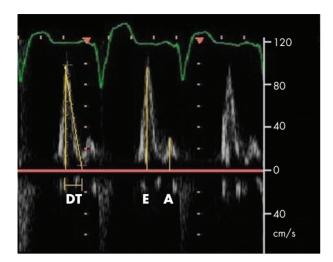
Example of restrictive mitral inflow pattern by Doppler echocardiography in a 61-year-old man with non-ischaemic cardiomyopathy with New York Heart Association class IV symptoms, who underwent cardiac transplantation three months later. E/A ratio = 3.1; deceleration time (DT) = 130 ms.
